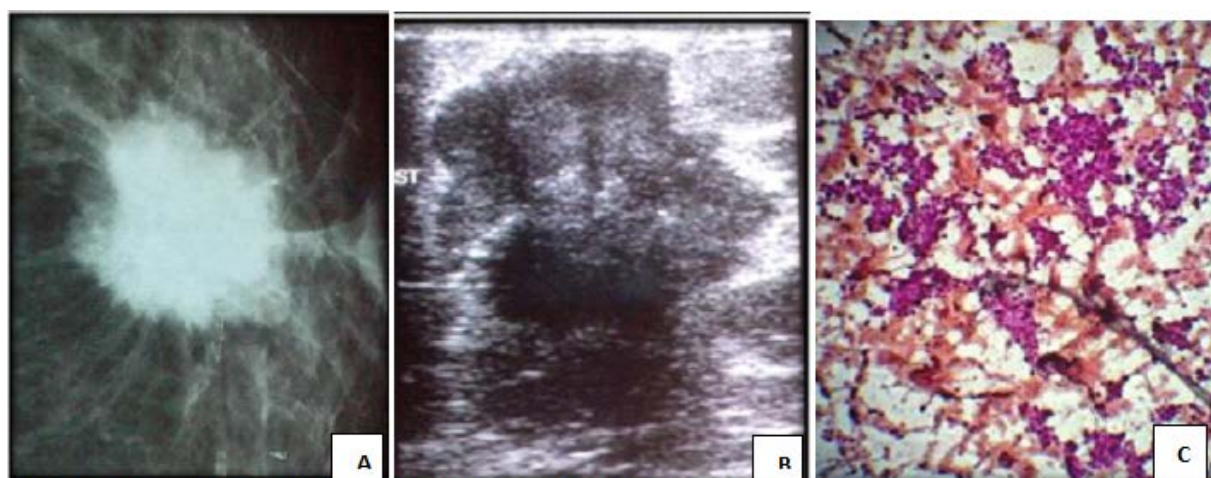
Mammography(A), sonography(B) and cytology(C) images of infiltrating duct carcinoma.
